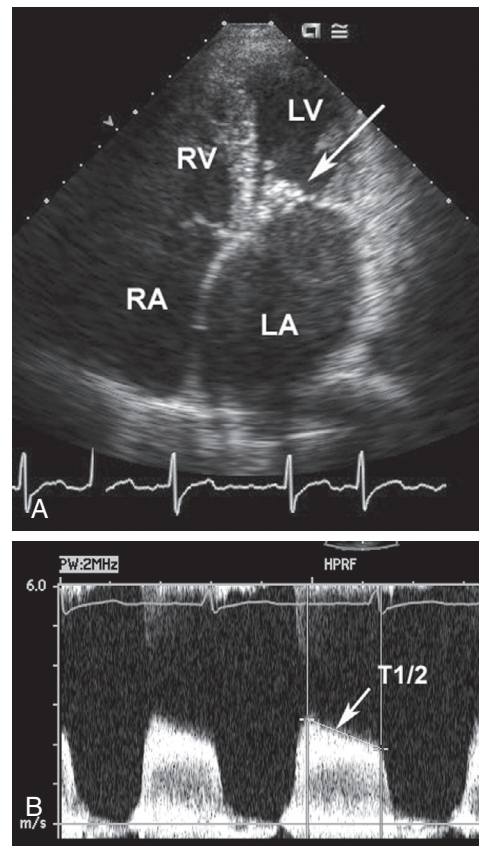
■ Same patient as Fig. 85-7. The apical four-chamber view (A) shows severe left atrial enlargement due to mitral obstruction, with thickened valve leaflets (arrow). Haziness in the left atrium is due to the stasis of blood flow, with spontaneous contrast on echocardiography. (B) Continuous-wave Doppler recording of flow across mitral valve shows increased velocity corresponding to transvalvular pressure gradient. Pressure half-time (T1/2) can be used to accurately calculate mitral valve area (0.7 cm^2).
